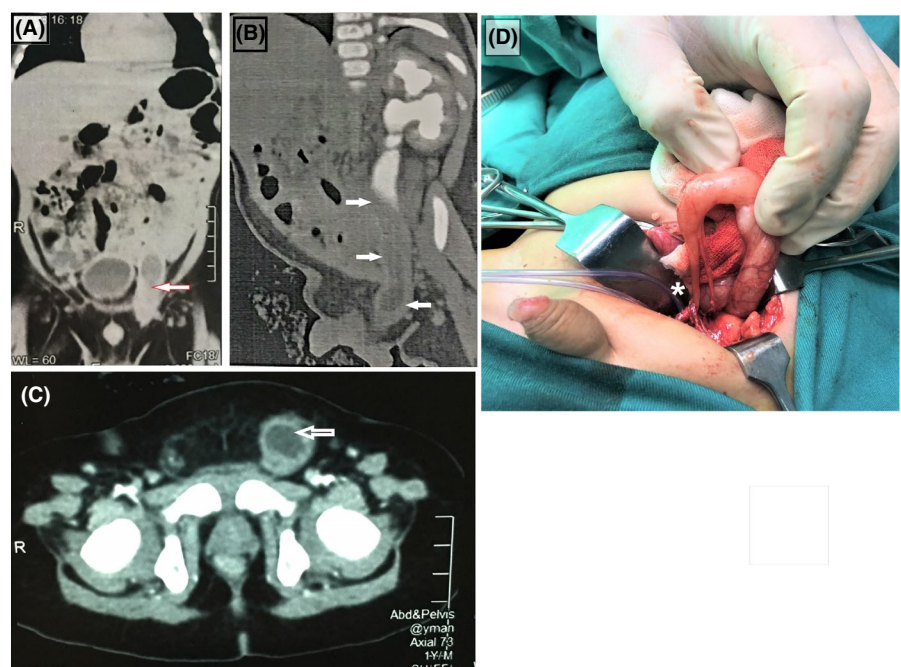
Abdominal computed tomography findings showing the hugely dilated ureter of congenital primary obstructed megaureter forming a left inguinal hernia in an infant (A, B, C, arrows). Intraoperative finding of the hugely dilated ureter with obstructed lower ureteric segment of congenital primary obstructed megaureter (D, asterisk)
